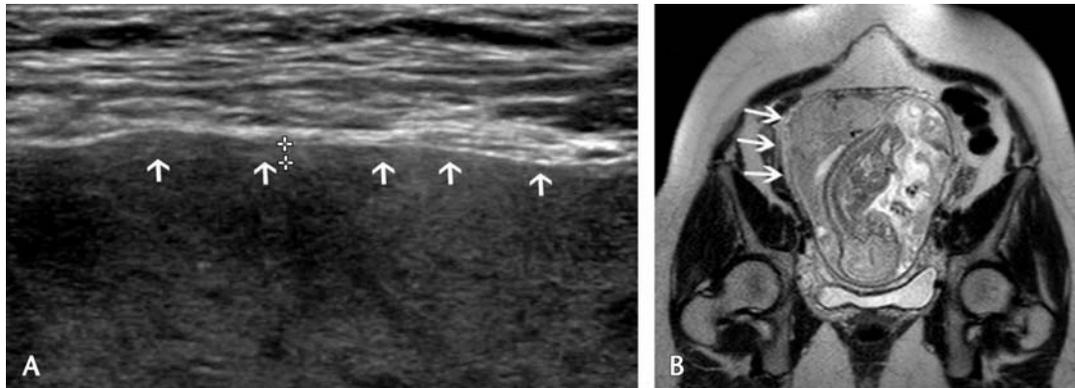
Placenta accreta. A, Transverse gray-scale ultrasound image obtained with a linear transducer along the anterior aspect of the uterus in a patient at 32-week gestation with complete placenta previa (not shown), shows progressively deficient myometrium (short arrows) extending to the bladder and uterine interface (not shown here). B, Coronal single-shot fast spin-echo MR image in a patient with constant left-sided abdominal pain during pregnancy, whose ultrasound examination was concerning for placenta accreta, shows gradual thinning with subsequent disappearance of the hypointense signal of the subplacental myometrium off to the right (arrows). Both cases were proven positive for placenta accreta at the time of cesarean delivery.
